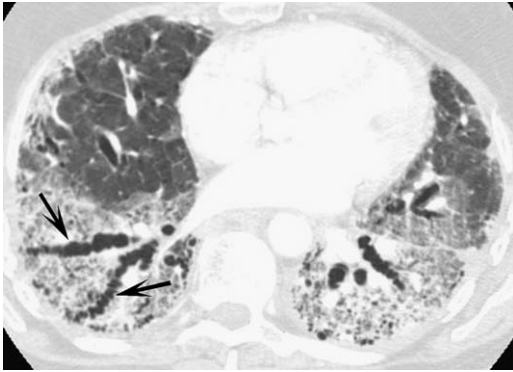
Pitfalls in the HRCT assessment of bronchiectasis: traction bronchiectasis. Axial HRCT image shows extensive lower lobe bronchial dilation (arrows). Note corrugated appearance of bronchi; this morphology is characteristic of traction bronchiectasis. Surrounding architectural distortion, ground-glass opacity, and coarse reticulation are present and suggest presence of fibrotic lung disease. Bronchi are also visible in the immediate subpleural regions of lung. This finding indicates an abnormal condition, and may be seen with traction bronchiectasis or primary large and small airway diseases.
